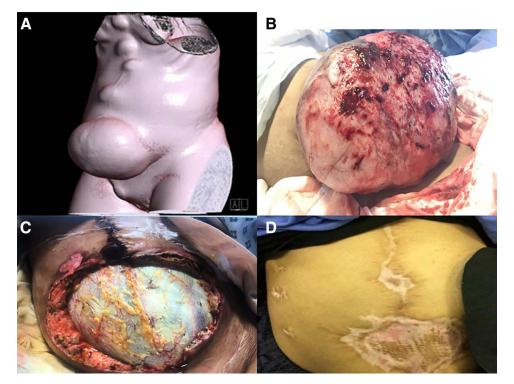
Patient presenting with an extensive desmoid disease that infiltrated the abdominal wall. The patient underwent an extensive abdominal wall/intestinal resection and received a fascia and intestinal graft: (A) extensive disease on CT reconstruction, (B) intraoperative image, (C) immediate postoperative situation, (D) status after 3 mo of vacuum-assisted closure therapy with skin graft.
